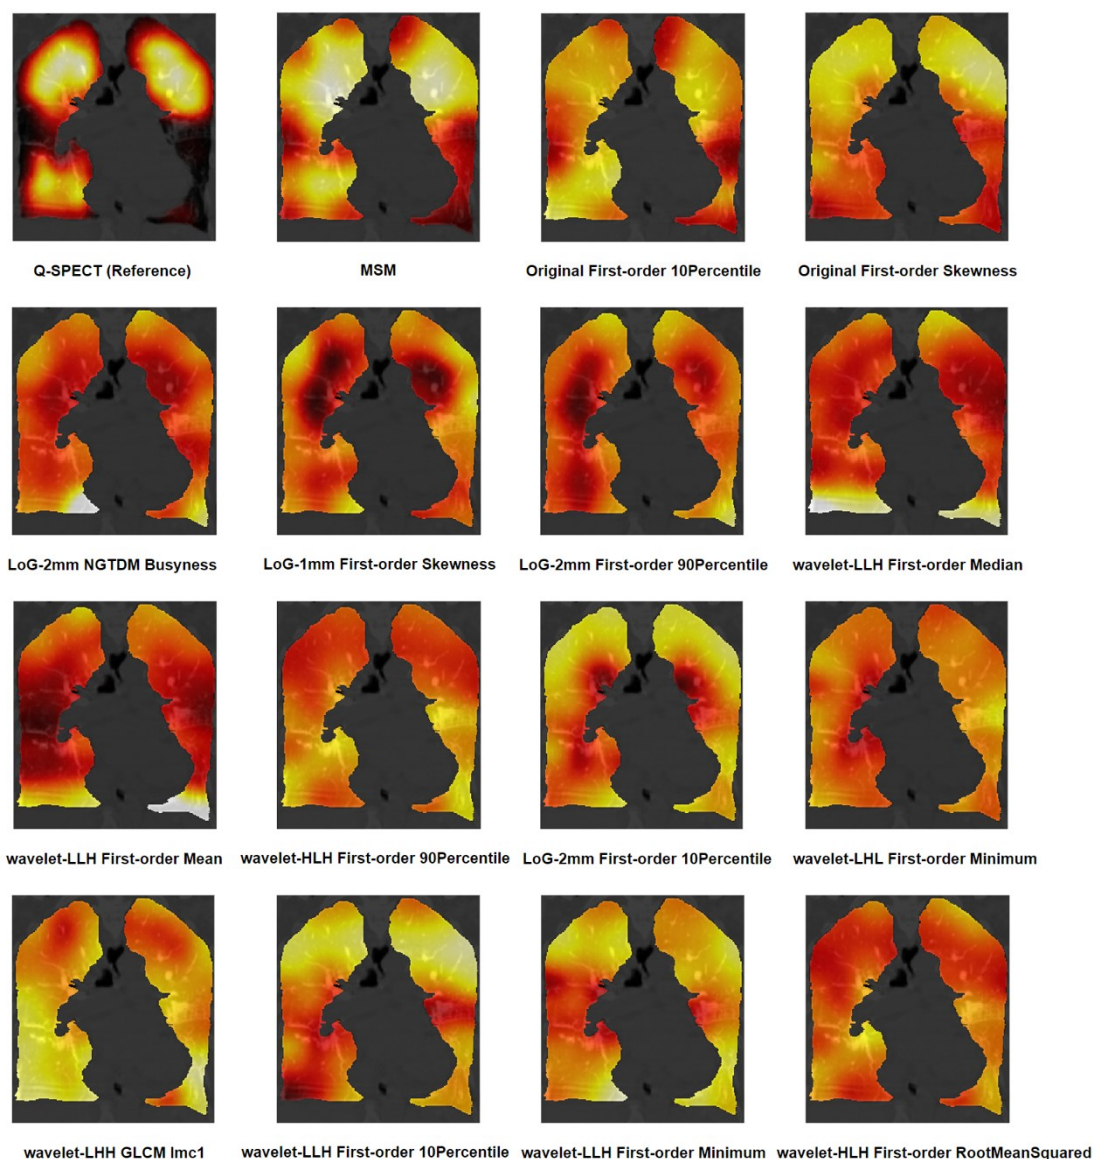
Reference Q-SPECT scan, feature maps of the 14 selected features from the final feature combination and MSM of a representative subject with pulmonary embolism disease.
